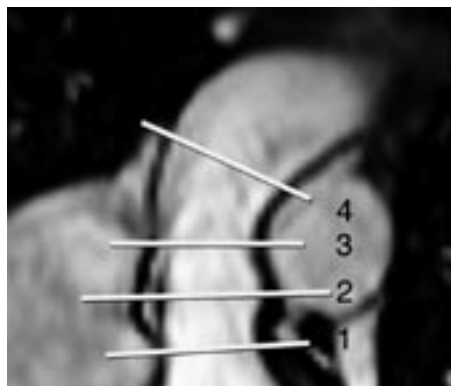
MR image obtained with steady-state free precession cine sequence in 16-year-old healthy male control subject shows four diameter measurements of the aortic root performed at (1) the level of the annulus of the aortic valve, (2) the sinus of Valsalva, (3) the sinotubular junction and (4) the ascending aorta (at the level of the crossing of the right pulmonary artery).
